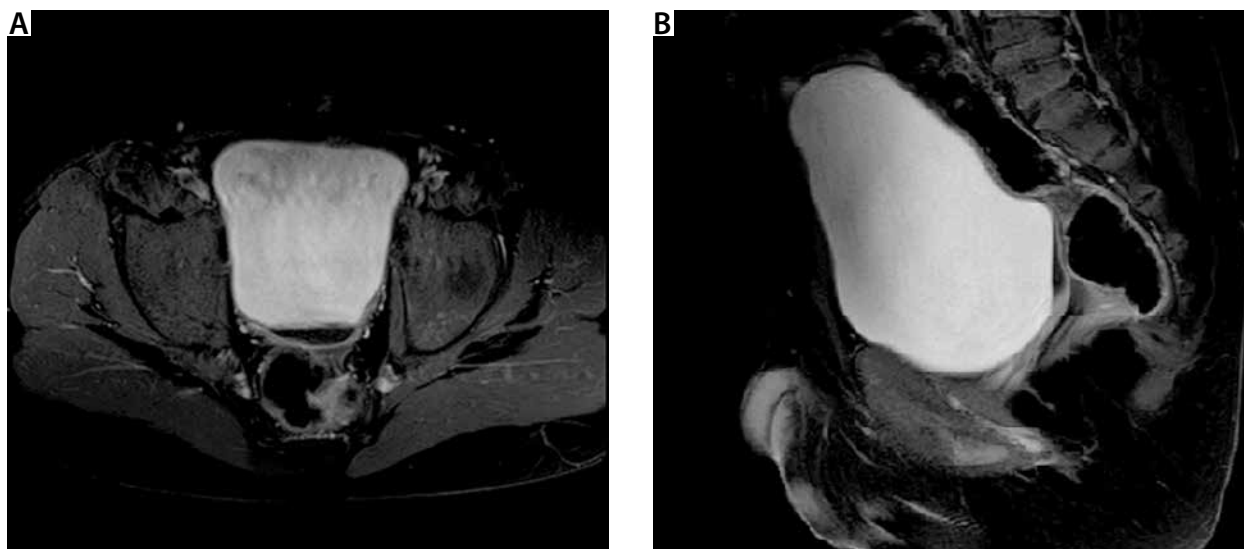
Follow-up magnetic resonance imaging after 3 months
